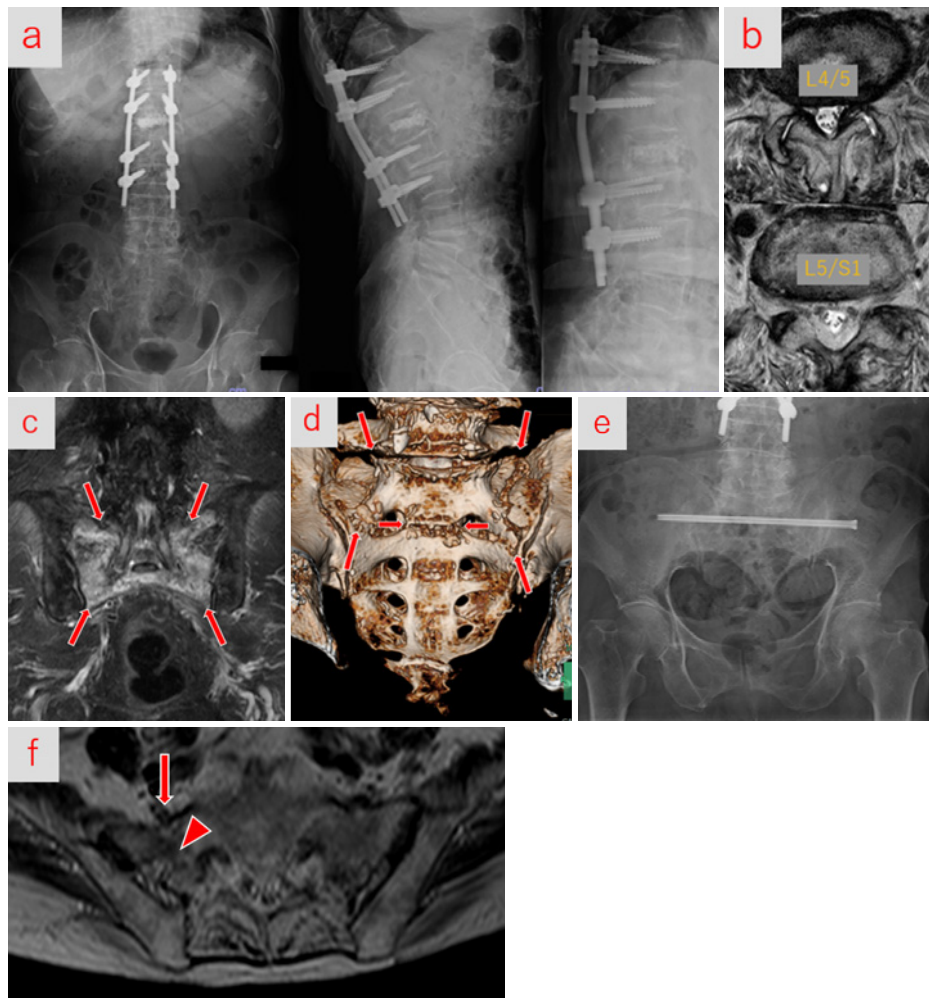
Case 3. a. Preoperative radiography showed no new fractures in the lumbar spine, implant loosening, or adjacent vertebral body fracture. b. The magnetic resonance imaging (MRI) of the lumbar spine showed L4/5 canal stenosis. c. T2-weighted MRI showed a sacral alar and S2 vertebral body fracture (arrows). d. Computed tomography (CT) revealed a minimally displaced sacral alar and S2 vertebral body fracture, Denis classification Zones I–III, Rommens classification Type IVb, AO classification Type C0 (arrows). e. Postoperative plain radiography after osteosynthesis using transiliac-transsacral screw (TITS). f. T2-weighted MRI showed the right L5 nerve root (arrow) was near the site of sacral fracture (arrowhead).
